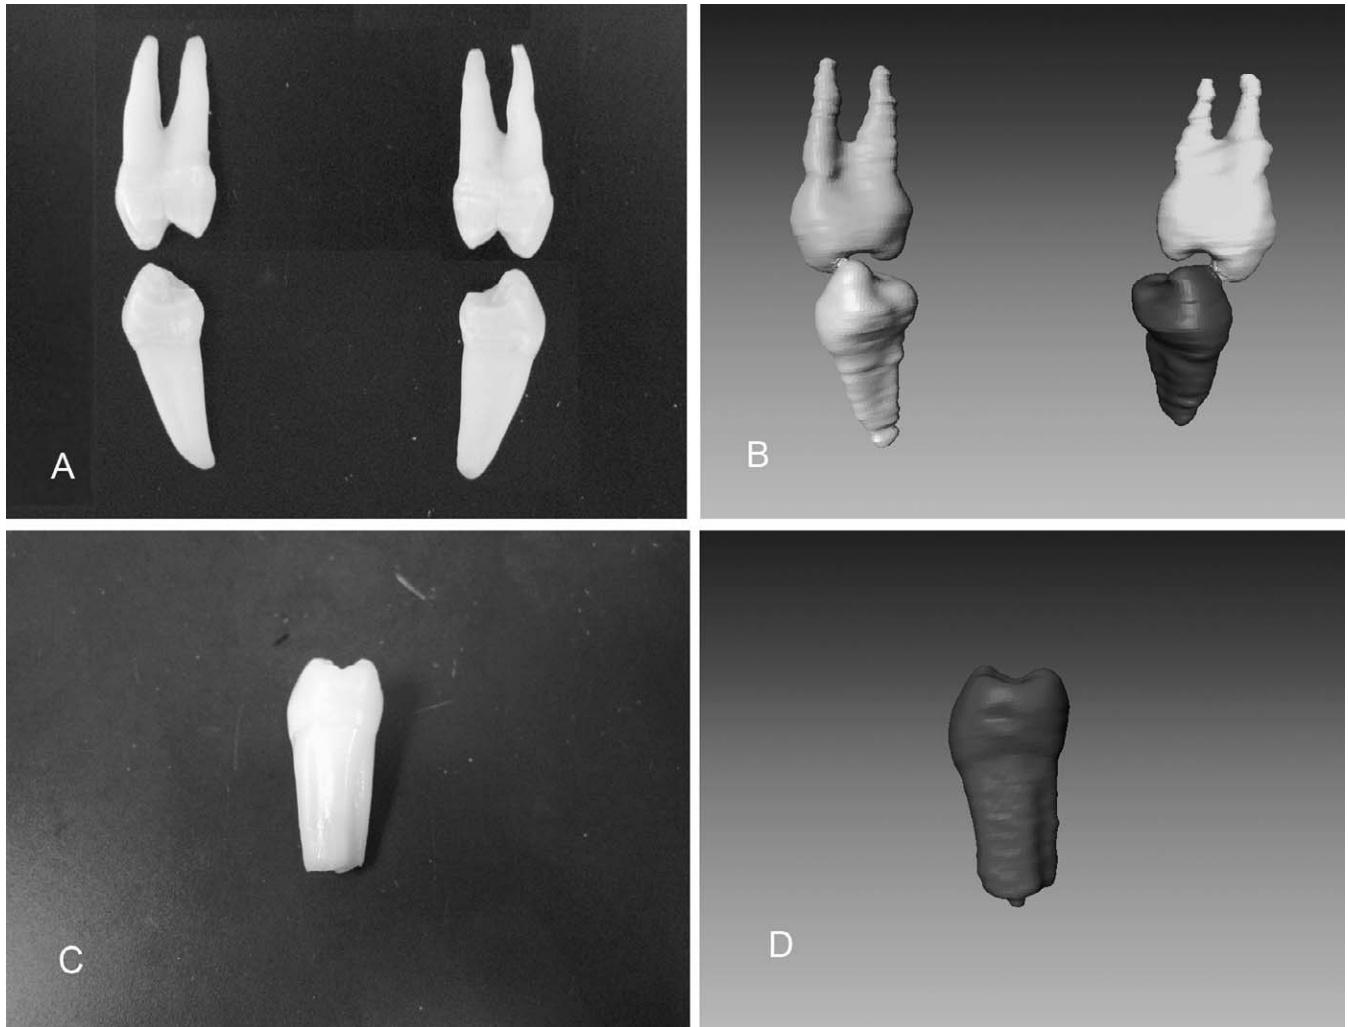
Virtual segmented teeth compared with physical teeth. (A) Physical four bicuspid, two roots for upper bicuspid. (B) Four bicuspid segmented from cone-beam computed tomography data sets. (C) Lower bicuspid with developing apex. (D) Apex can be seen clearly in segmented tooth.
